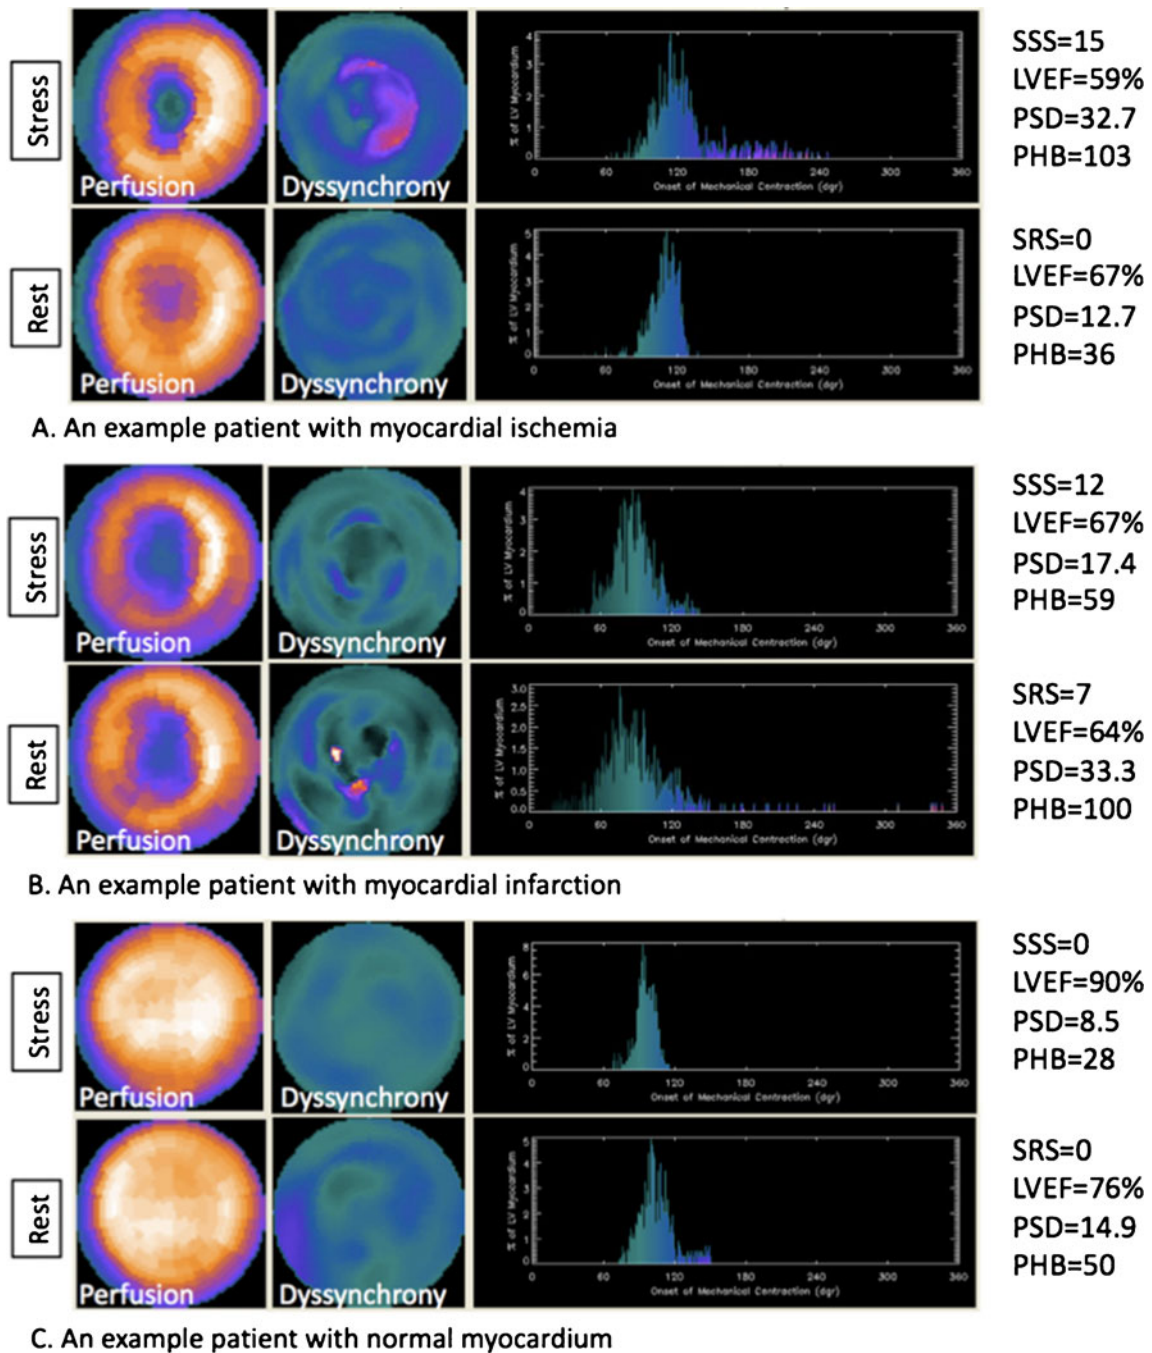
Gated SPECT MPI images in example patients with ischemic (a), infarcted (b) and normal (c) myocardium
